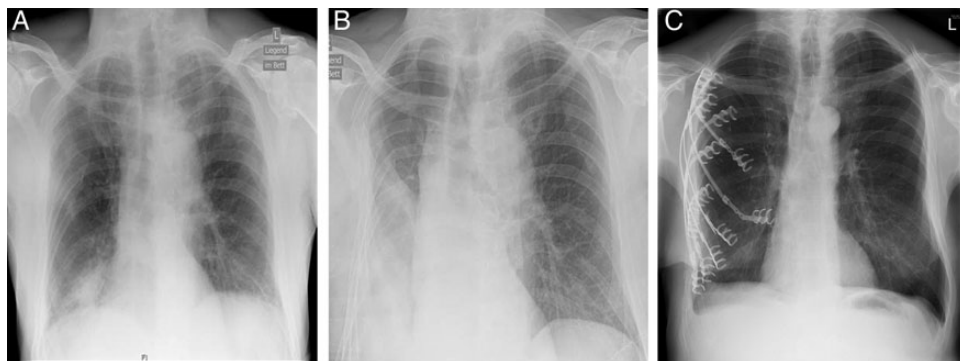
(A) Chest X-ray with dislocated rib fractures on the right side. The patient received analgesia with epidural catheter and was transferred to the normal ward. (B) Progressive shrinkage with reduction of the volume of the right hemithorax. The patient developed acute respiratory insufficiency. He was transferred to the intensive care unit and was intubated. (C) Chest X-ray after ORIF showing a well-shaped right hemithorax.
